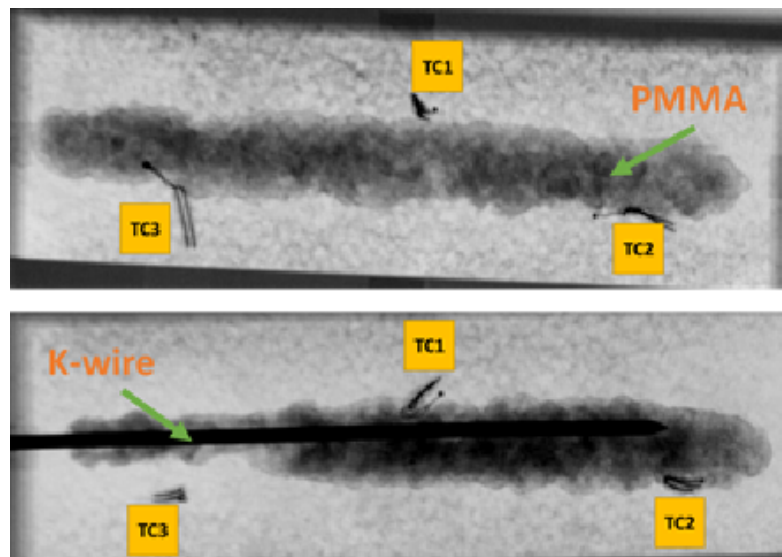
X-ray images of PMMA profile inside the open cell foam block (Sawbone) without cooling(top) vs. with cooling (bottom). Note that the location of thermocouples (TC1, TC2, and TC3) were the same in both experiments.
